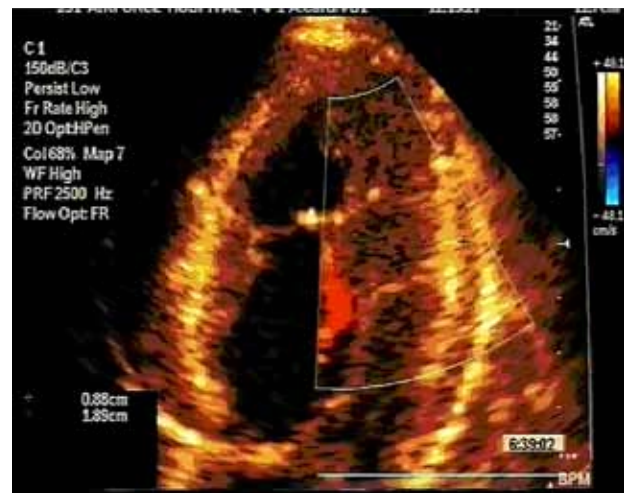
Two-dimensional echocardiogram, four-chamber apical view. The colour flow demonstrated communication between intertrabecular spaces and the left ventricular cavity. The ratio of non-compacted to compacted zone during the end-systolic phase of the cardiac cycle was >2.14 .
